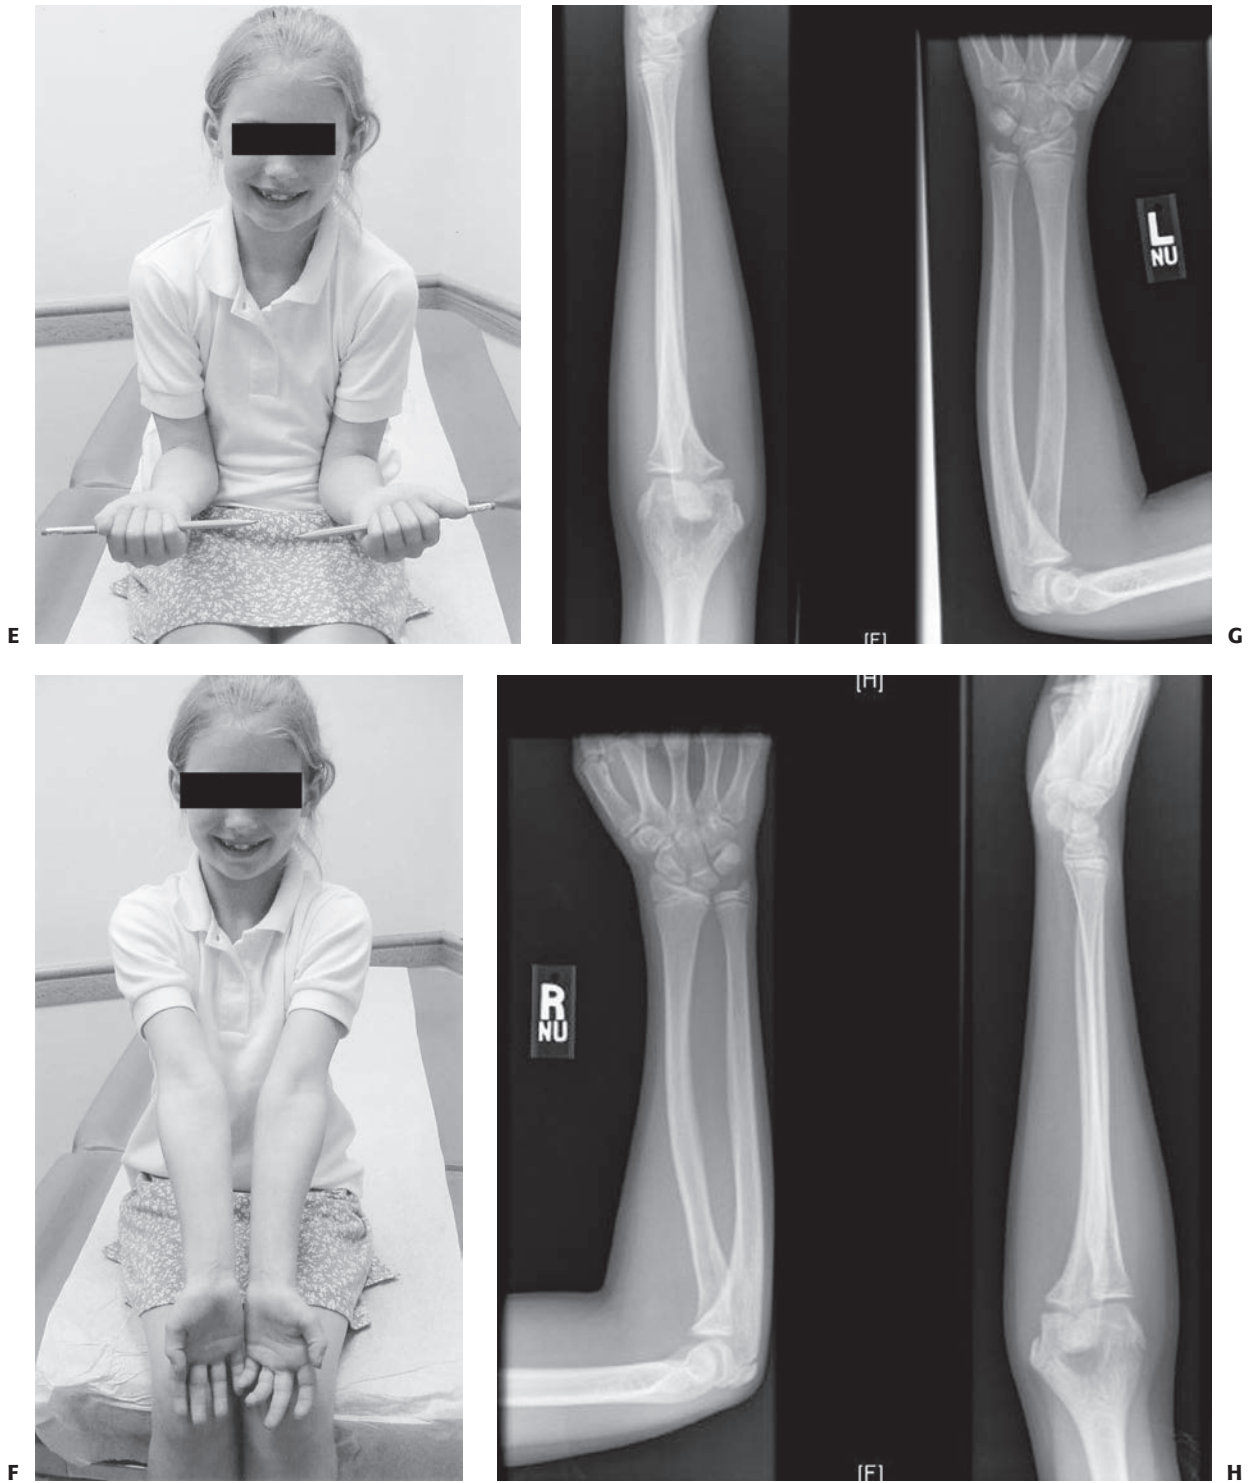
(continued) E: Supination. F: Axial alignment at 2-year follow-up. G: Five-year follow-up radiographs of left forearm with mild loss of radial bow. H: Comparison radiographs of right forearm.
